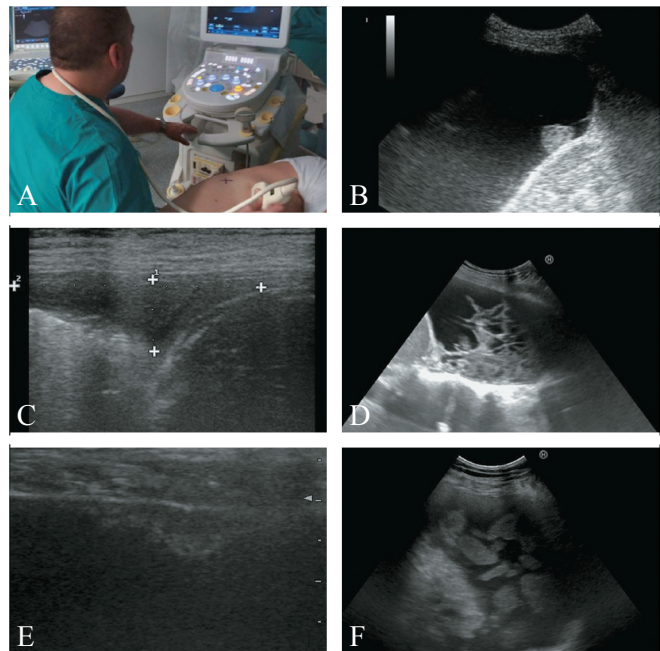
Ultrasound-guided medical thoracoscopy access: A) operator performing chest ultrasound looking for the right thoracoscopic entry side; B) pleural effusion and nodule on the diaphragm; C) small amount of pleural effusion in costo-phrenic angle; D) pleural effusion with alveolar appearance; E) pleural nodule in the absence of pleural effusion; F) ultrasound appearance of clots in hemothorax.
